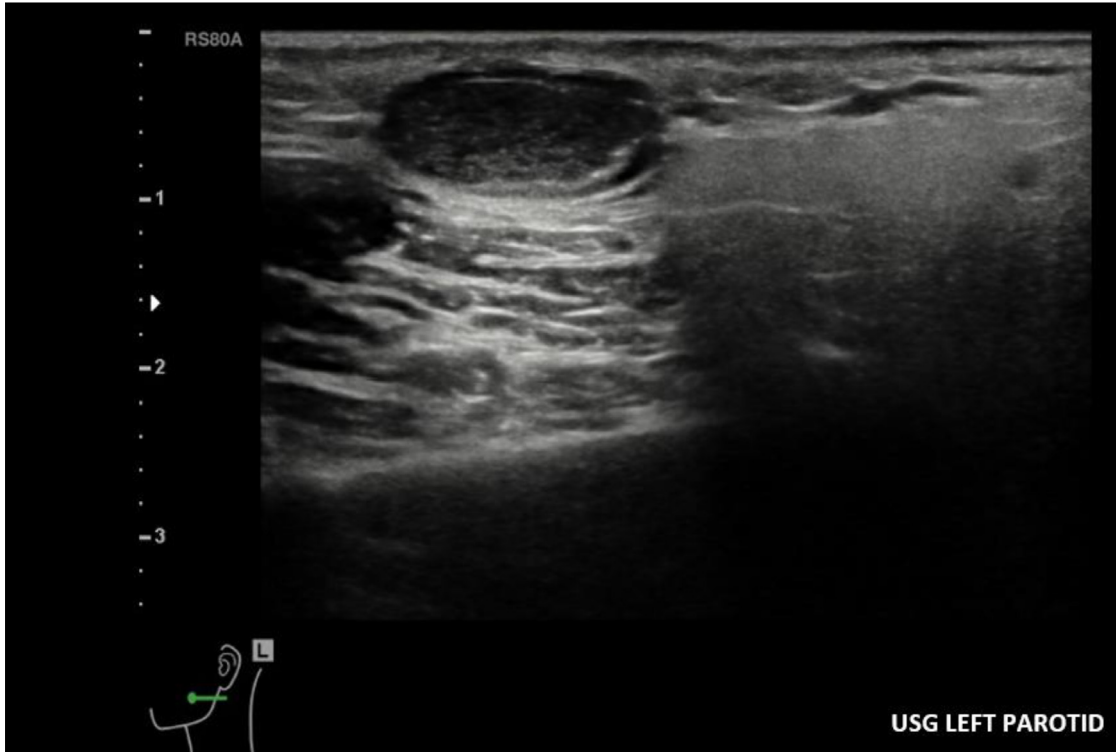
Ultrasound guidance (USG): long axial view of a well-defined subcutaneous lesion in the left parotid region, appearing hypoechoic.
